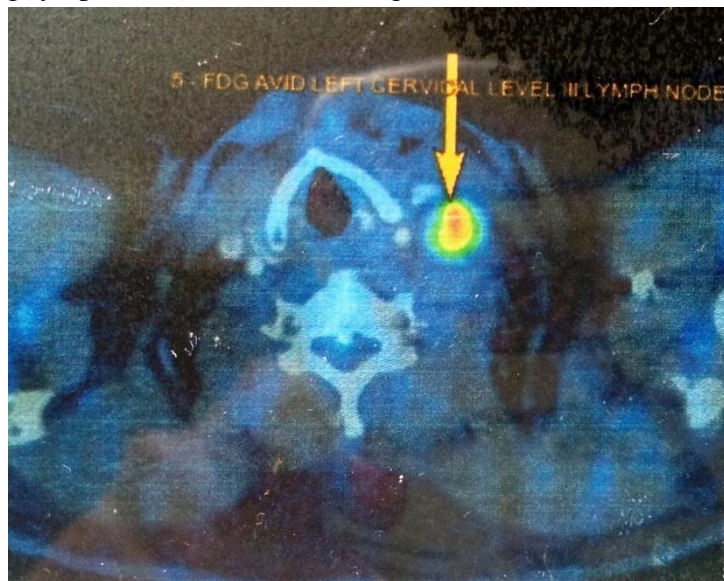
F-FDG PET/CT showing moderate to intensely FDG left cervical level II lymph nodes suggesting lymph nodal metastases.
